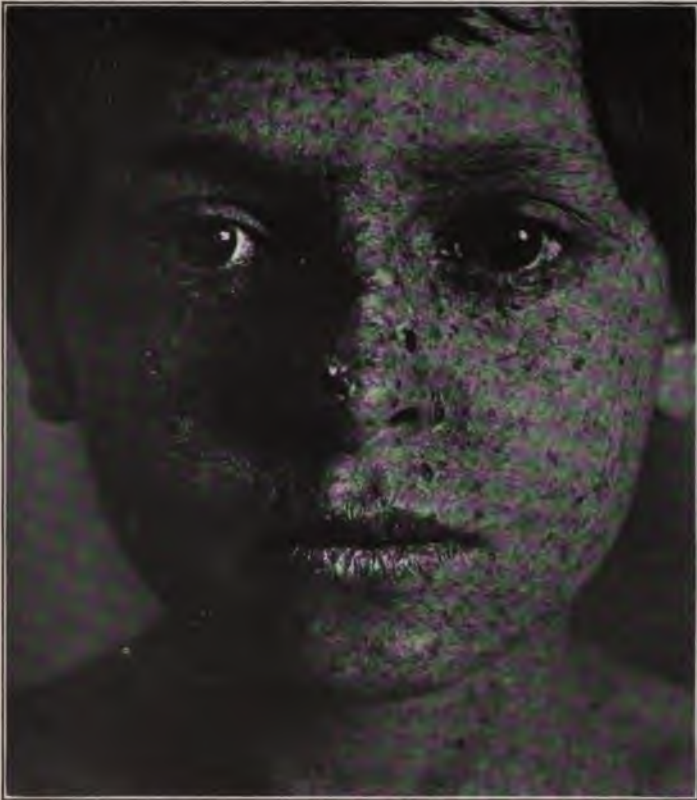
Xeroderma pigmentosum, showing telangiectasia, pigmentation, keratoses and epitheliomata. Note the similarity to the so-called x-ray skin.
